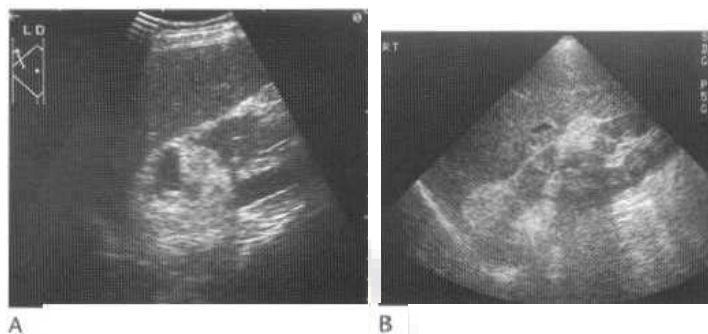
Ultrasound appearances of angiomyolipomas. (A) Large lower pole predominantly echogenic mass (solitary angiomyolipoma). (B) Multiple well-defined purely echogenic masses (multiple angiomyolipomas in tuberous sclerosis).
